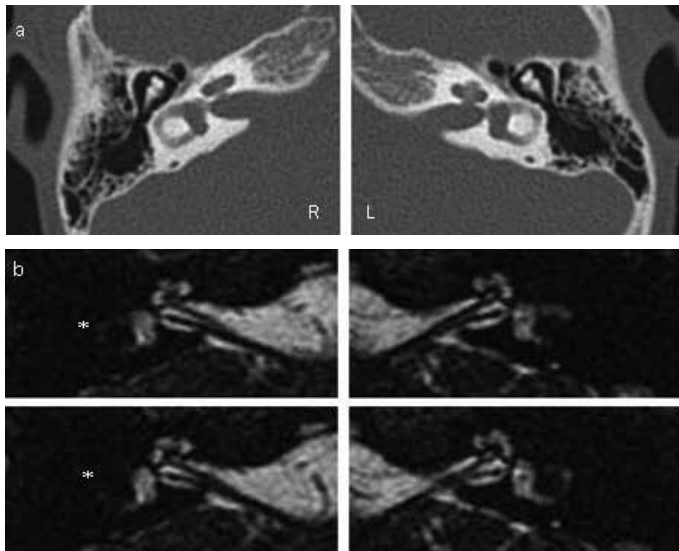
a, b. Inner ear imaging before CI surgery: temporal bone high-resolution computed tomography (HRCT) with apparently normal appearance on both sides (a); MRI showing decreased T2-weighted signal at the level of the semi-circular canals.
